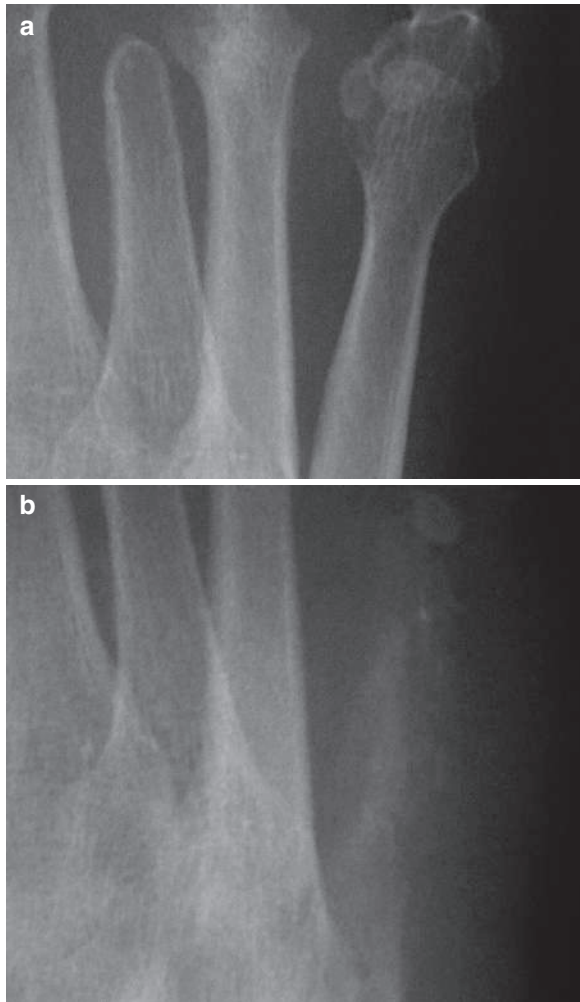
Plain foot radiographs of a patient with diabetic foot show acute osteomyelitis. In (a), the patient was investigated for a pain in the fifth toe, which shows mild osteoporosis compared to the rest of the metatarsals (note the third toe amputation). After 3 months, the patient showed moth-eaten osteomyelitis bone destruction of the fifth metatarsal bone, with complete cortical destruction
